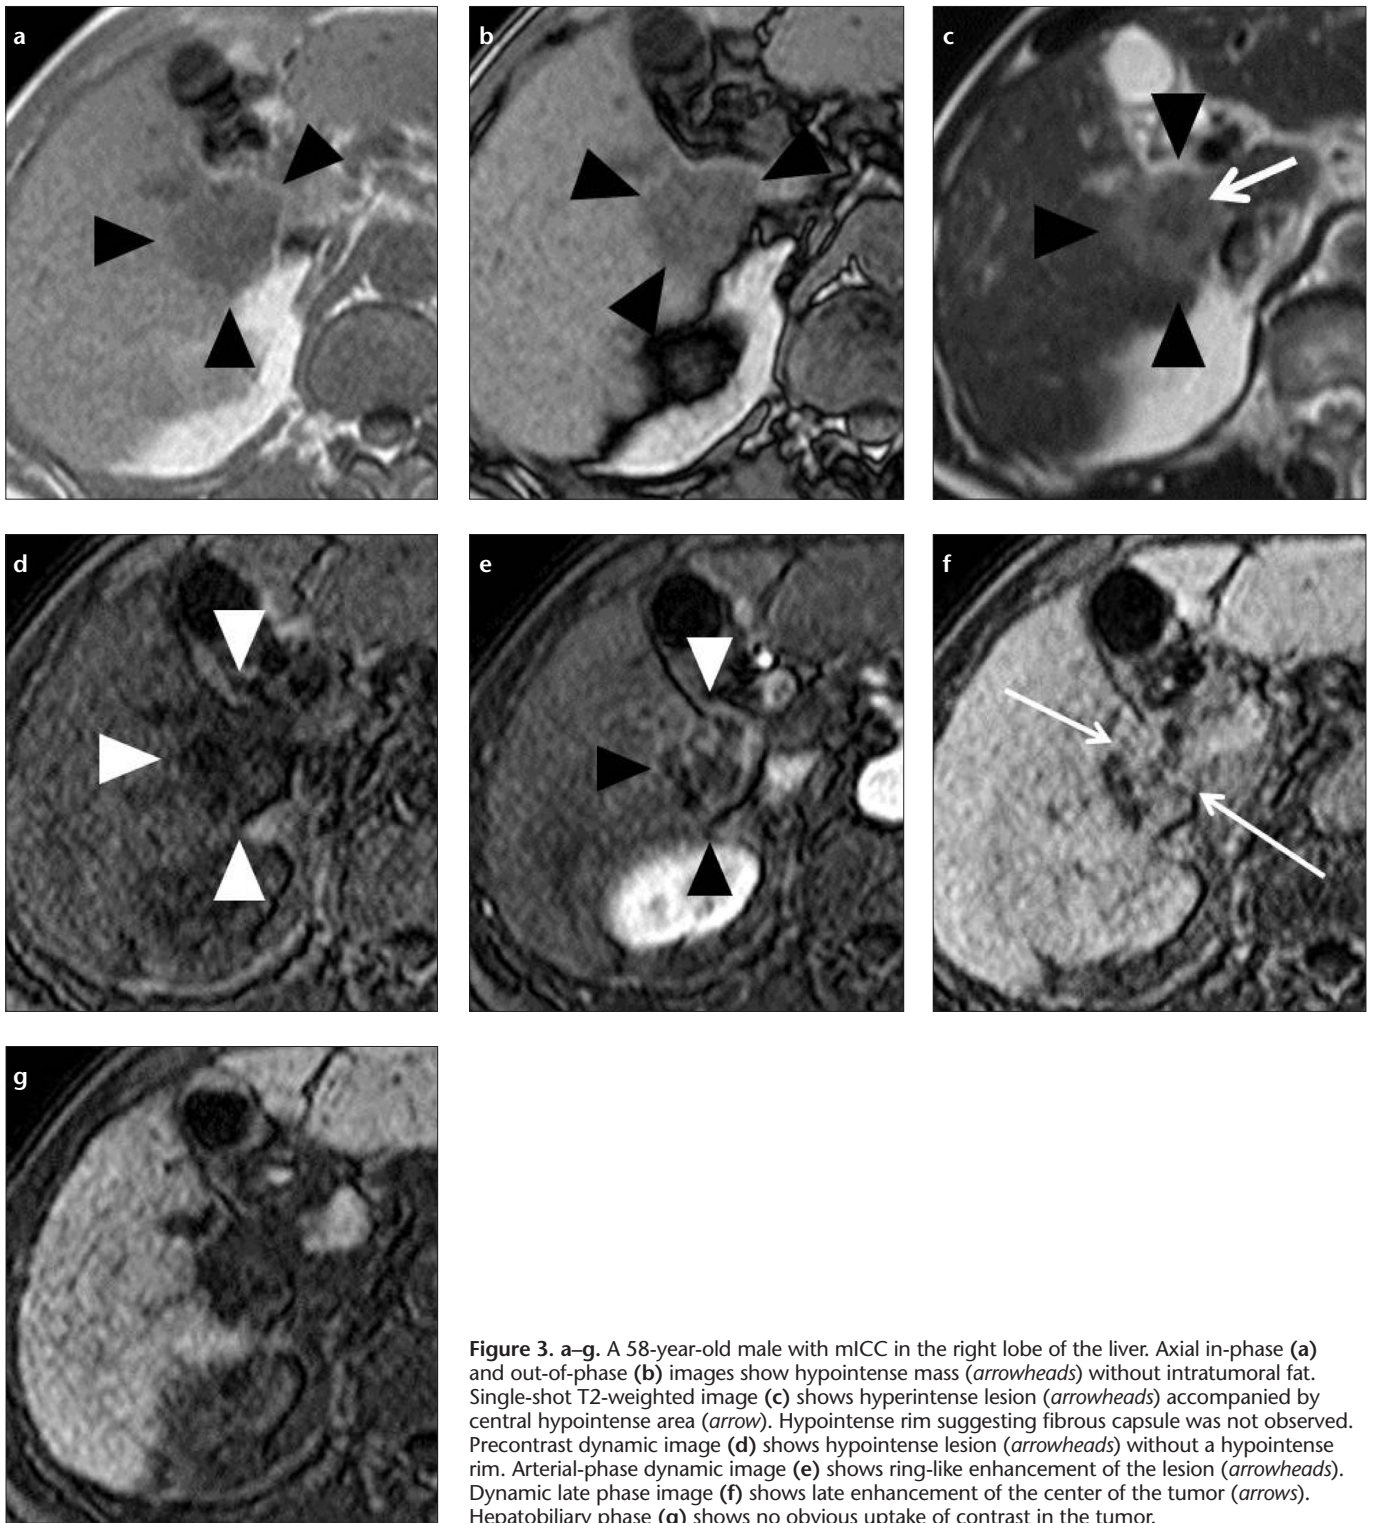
a–g. A 58-year-old male with mIHC in the right lobe of the liver. Axial in-phase (a) and out-of-phase (b) images show hypointense mass (arrowheads) without intratumoral fat. Single-shot T2-weighted image (c) shows hyperintense lesion (arrowheads) accompanied by central hypointense area (arrow). Hypointense rim suggesting fibrous capsule was not observed. Precontrast dynamic image (d) shows hypointense lesion (arrowheads) without a hypointense rim. Arterial-phase dynamic image (e) shows ring-like enhancement of the lesion (arrowheads). Dynamic late phase image (f) shows late enhancement of the center of the tumor (arrows). Hepatobiliary phase (g) shows no obvious uptake of contrast in the tumor.
